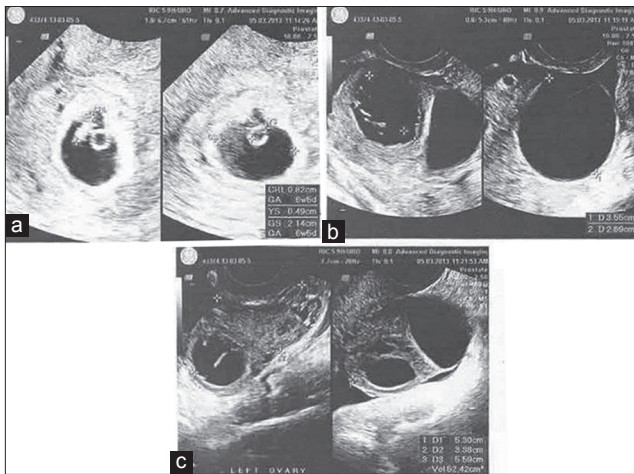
(a) Ultrasound image showing intrauterine gestation. (b) Ultrasound image showing enlarged right ovary with cysts. (c) Ultrasound image showing enlarged left ovary with cysts
